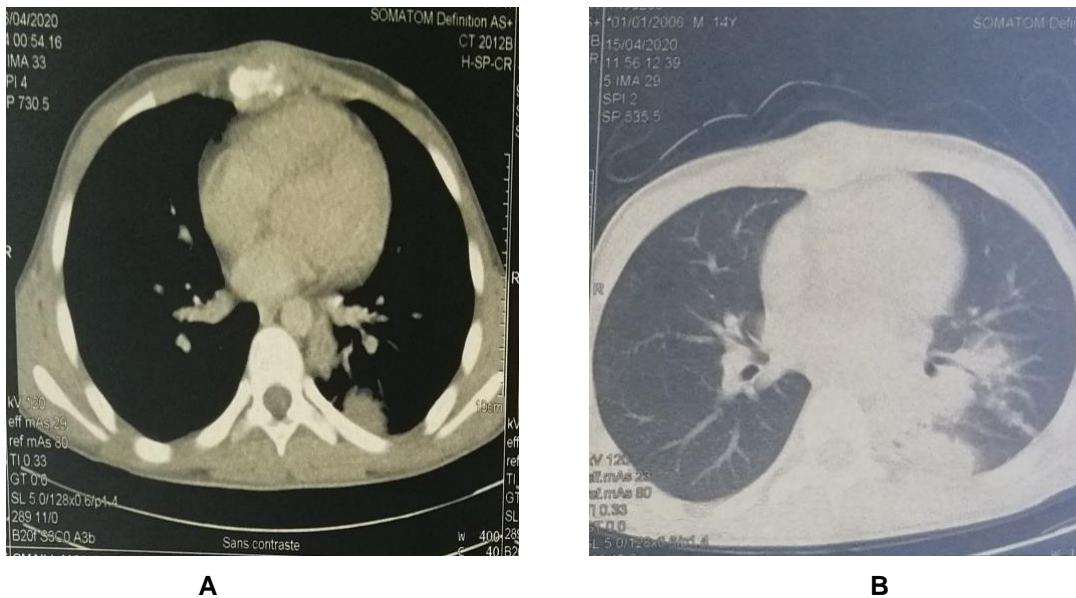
Computed tomography images demonstrating the image of lytic presternal lesion with infiltration of the mediastinum and soft tissue opposite (A), and a systematized condensation image of the left lung associated with interstitial micronodules (B)
